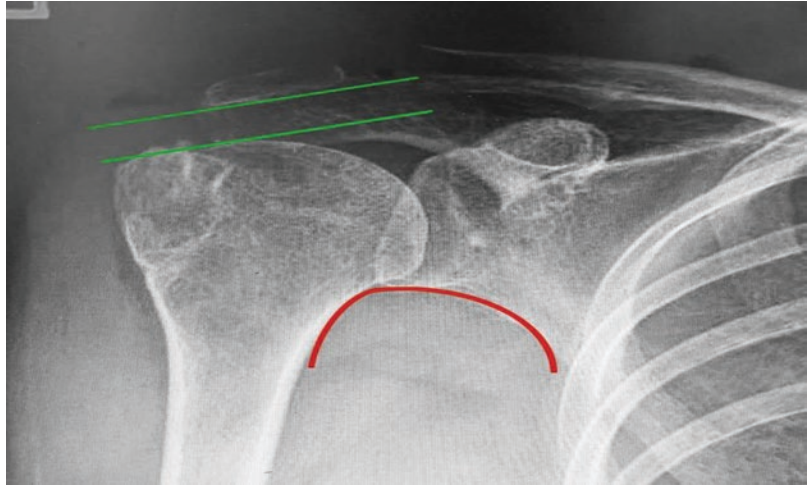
Radiographs of patient with recurrent tear. The shoulder AP radiograph shows metal artefacts in the humeral head, which is high riding with an acromial humeral interval (AHI) <6 mm. There are mild degenerative changes. These changes on the plain radiograph suggest a recurrent tear of the tendon
